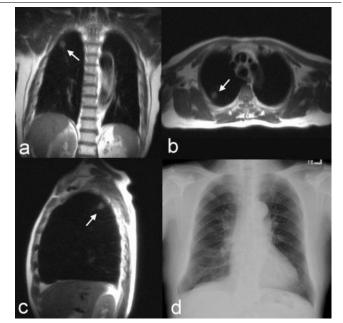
The HASTE images from MRI
